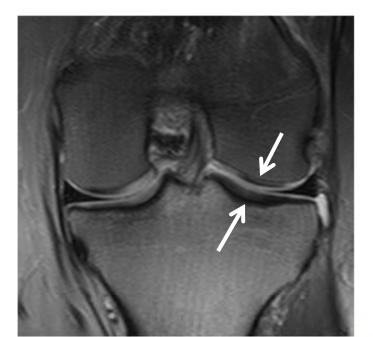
Coronal PD-weighted 3.0 T MRI (TR/TE = 3200 ms/30 ms) demonstrating a normal spatial variation in cartilage signal intensity. Cartilage habitually exposed to high compressive strain demonstrates a thick, highly anisotropic radial zone which appears as low signal intensity (arrows). In contrast the more peripheral cartilage has a thinner radial zone and wider transitional zone
